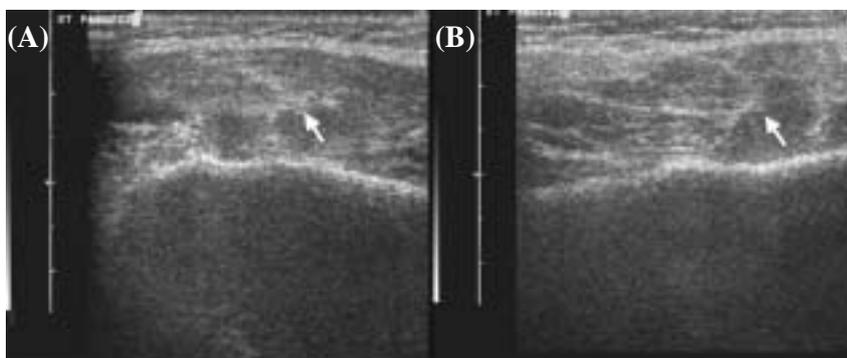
Sonography of right parotid gland: hyperechogenic (arrow) swelling of parotid gland and no dilatation of parotid duct. (A) Transverse view. (B) Longitudinal view.
